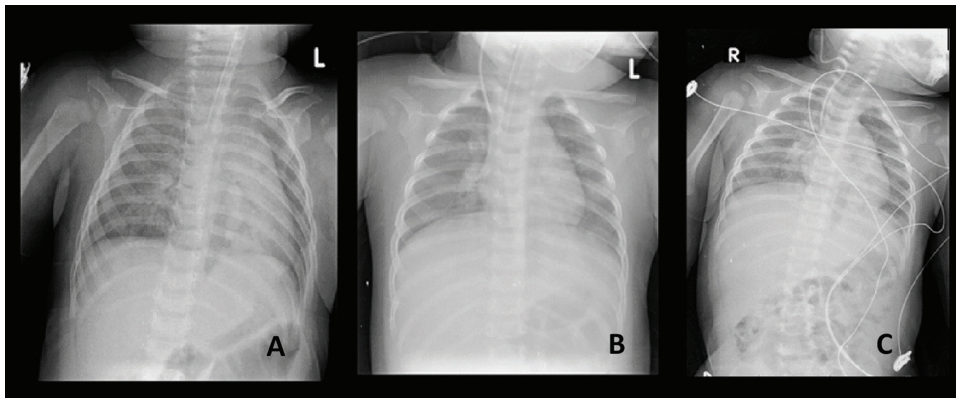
Chest radiograph of the patient (case 2). (A) Portable chest radiograph revealed perihilar infiltration of both lungs and left lower lung atelectasis after intubation. (B) 72 hours after PICU admission, portable chest radiograph showed decreasing infiltration and hyperinflation. (C) 5 days after PICU admission, the patient was extubated.
